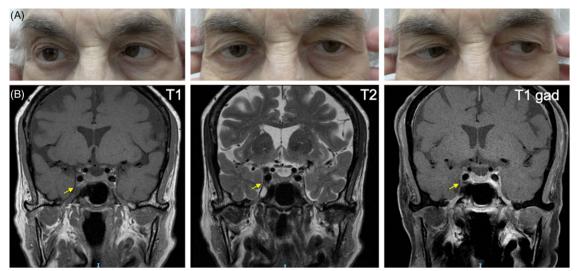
(A) External photographs demonstrating a limitation of abduction in the right eye. (B) Coronal magnetic resonance imaging (MRI) demonstrating enlargement in the right cavernous sinus (arrows), which was bulkier, dark on T2-weighted images, and without enhancement when compared to the left.
